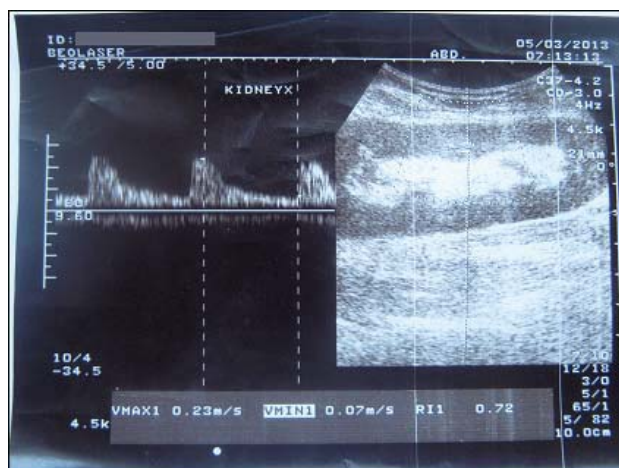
Graft Doppler ultrasonography one year after transplantation.
